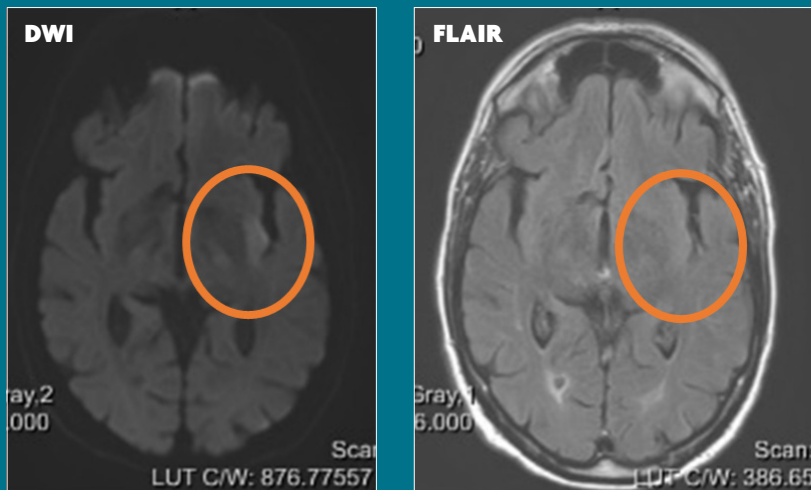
Left insular infarct (MCA territory). Mismatch DWI-FLAIR because DWI shows a high signal lesion and FLAIR a normal signal in the same area.
